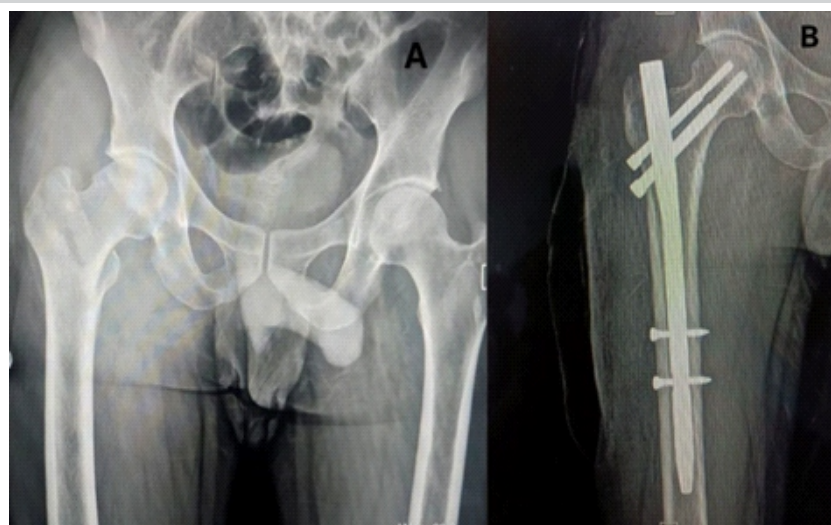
(a) Pre-operative anterior-posterior (A-P) view X-ray showing TYPE 31-A1.2 pertrochanteric femur fracture of the right side. (b) Post-operative A-P view X-ray showing pertrochanteric femur fracture fixed with short proximal femur nail.
